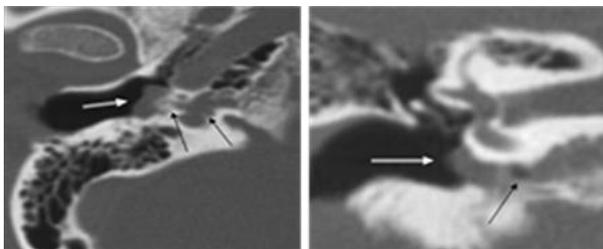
Paraganglioma (*glomus tympanicum*) (a) axial section (b) coronal section CT scan right temporal showing a mass with an even edge along the surface of the promontorium (white arrow), noted sublabryrin infiltration (black arrow)
